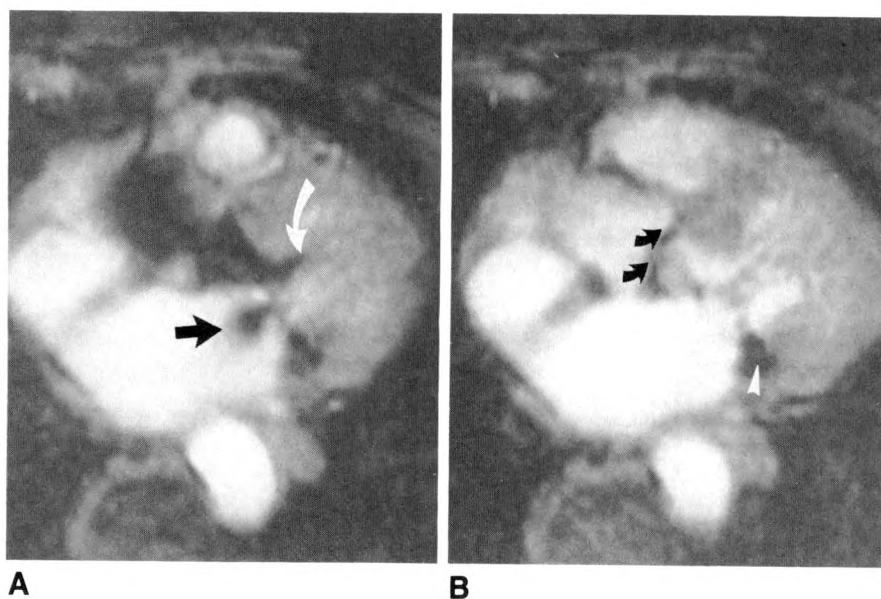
Systolic (A) and diastolic (B) transverse cine MR images through left ventricular outflow region of a patient with subaortic and aortic stenosis and accompanying mitral incompetence.
